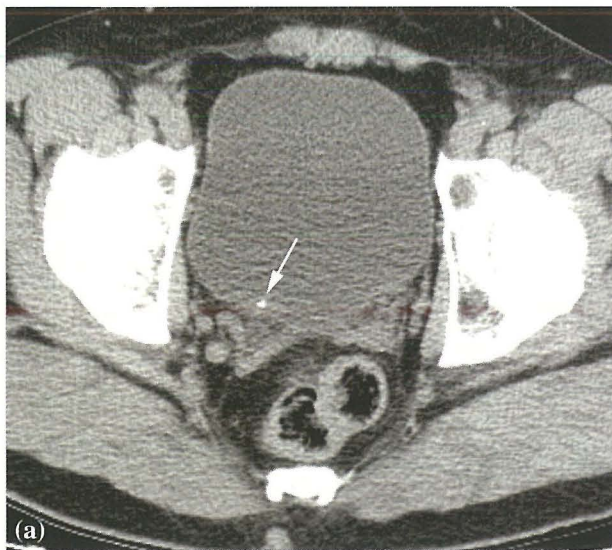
(a) Axial CT scan of a patient with right flank pain, obtained with the patient supine, shows a stone adjacent to the right posterior bladder wall. (b) On a scan obtained with the patient placed prone, the stone does not fall anteriorly, indicating the stone is still within the ureterovesical junction.
